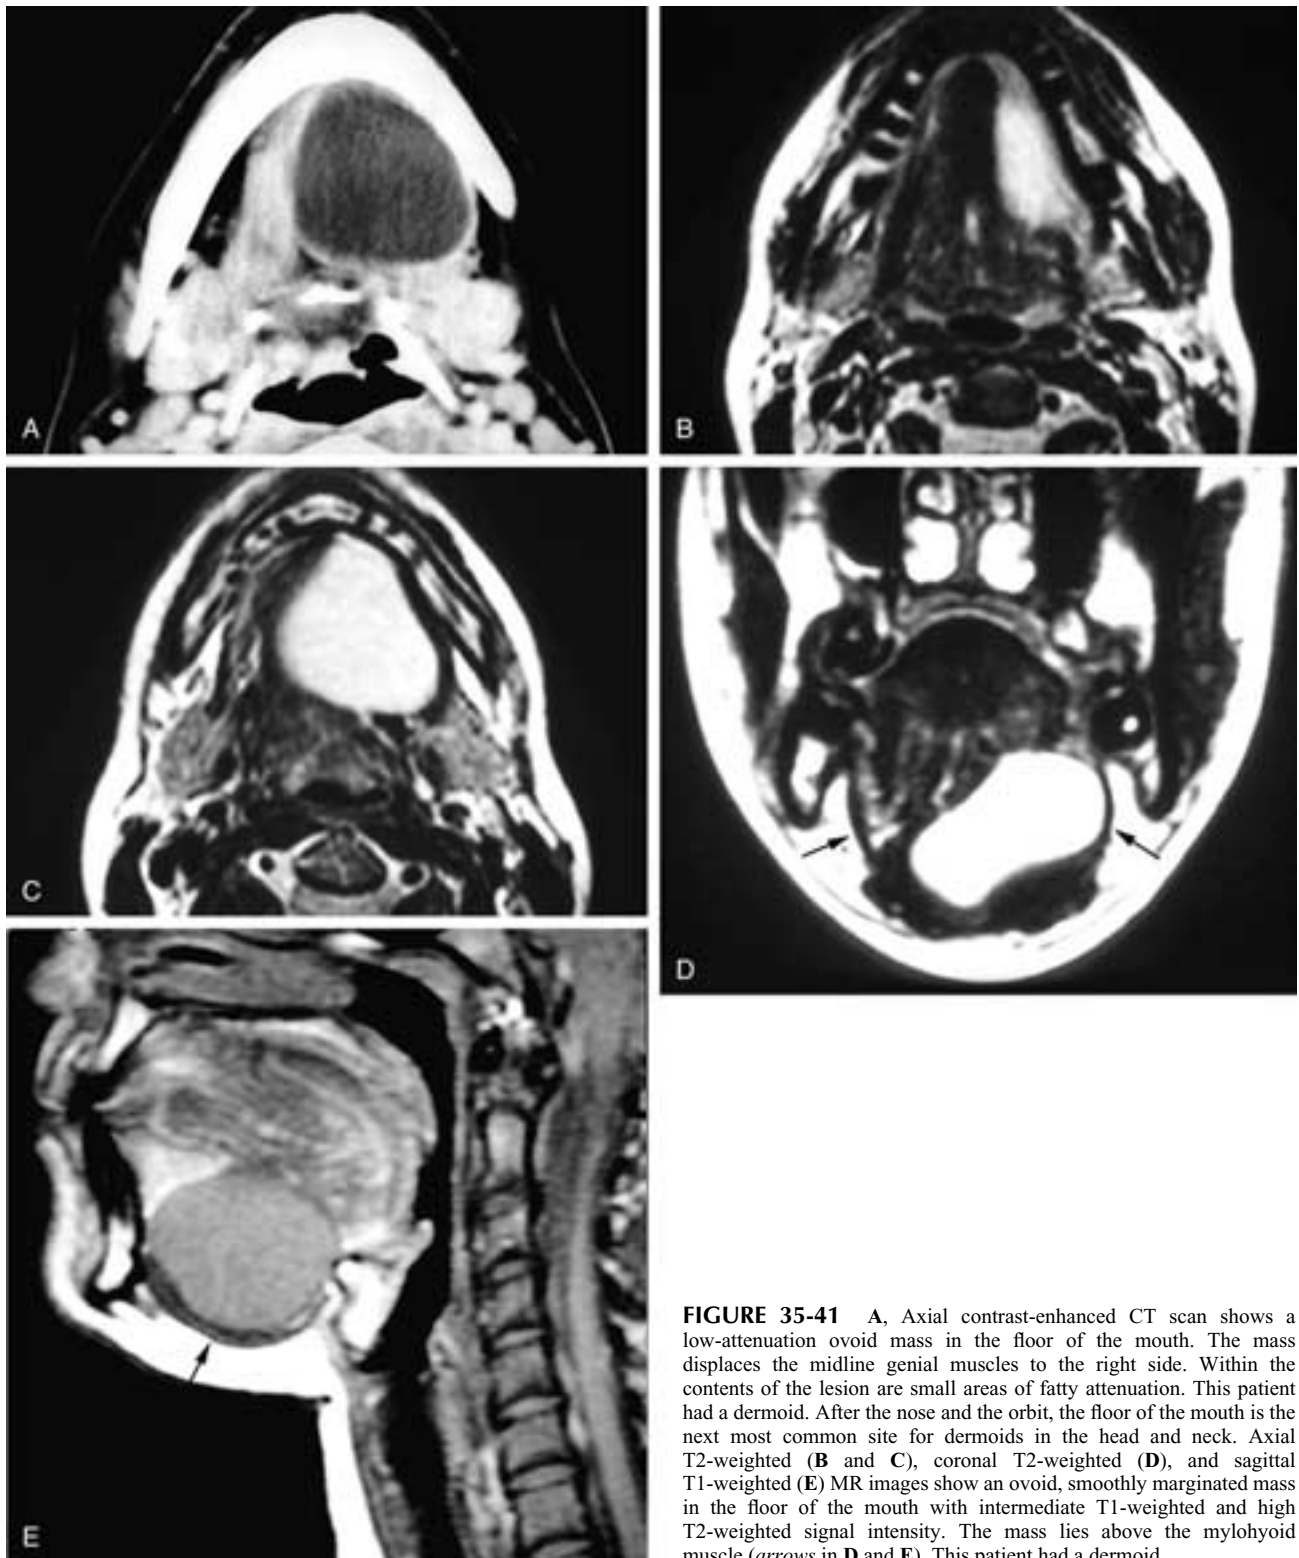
A, Axial contrast-enhanced CT scan shows a low-attenuation ovoid mass in the floor of the mouth. The mass displaces the midline genial muscles to the right side. Within the contents of the lesion are small areas of fatty attenuation. This patient had a dermoid. After the nose and the orbit, the floor of the mouth is the next most common site for dermoids in the head and neck. Axial T2-weighted (B and C), coronal T2-weighted (D), and sagittal T1-weighted (E) MR images show an ovoid, smoothly margined mass in the floor of the mouth with intermediate T1-weighted and high T2-weighted signal intensity. The mass lies above the mylohyoid muscle (arrows in D and E). This patient had a dermoid.
